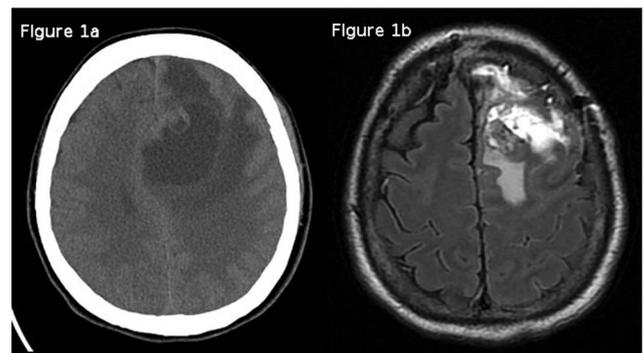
Neuroimaging of a frontal lobe glioblastoma mimicking psychiatric relapse. (a) Axial non-contrast computed tomography shows a left frontal cystic mass with a mural nodule, surrounded by vasogenic edema and associated with midline shift. (b) Axial fluid-attenuated inversion recovery (FLAIR) magnetic resonance imaging demonstrates a heterogeneous hyperintense lesion involving the left frontal lobe and cingulate gyrus, with extensive perilesional edema.
